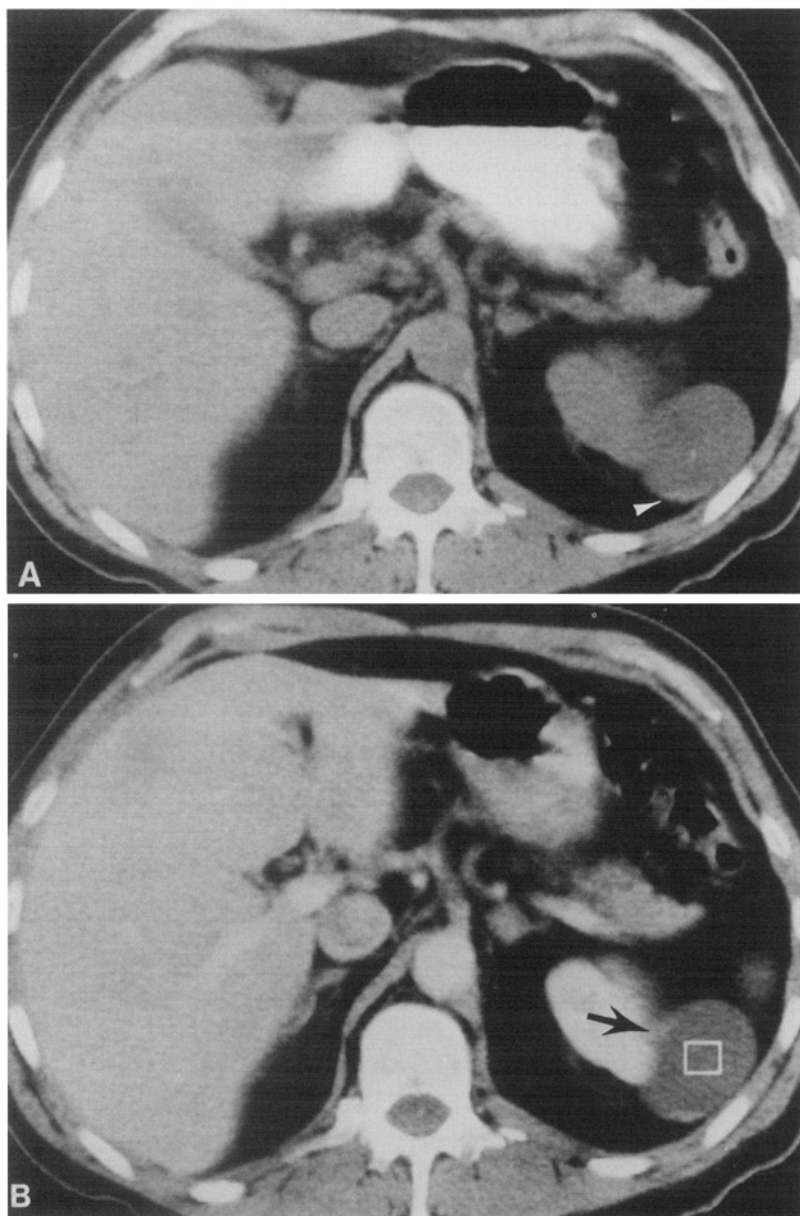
Focal wall thickening with enhancement (category IV). Unenhanced CT scan (A) shows a well-defined cystic mass with a focal thickening of its dorsal wall (*arrowhead*). On the enhanced CT scan (B) this thickened segment enhanced from 50 to 80 HU. The enhancement near the renal margin (*arrow*) could be a beak of normal enhancing parenchyma or a second area of wall thickening. At surgery, frozen sections were negative. Permanent sections demonstrated well-differentiated renal cell carcinoma lining the entire cyst.
